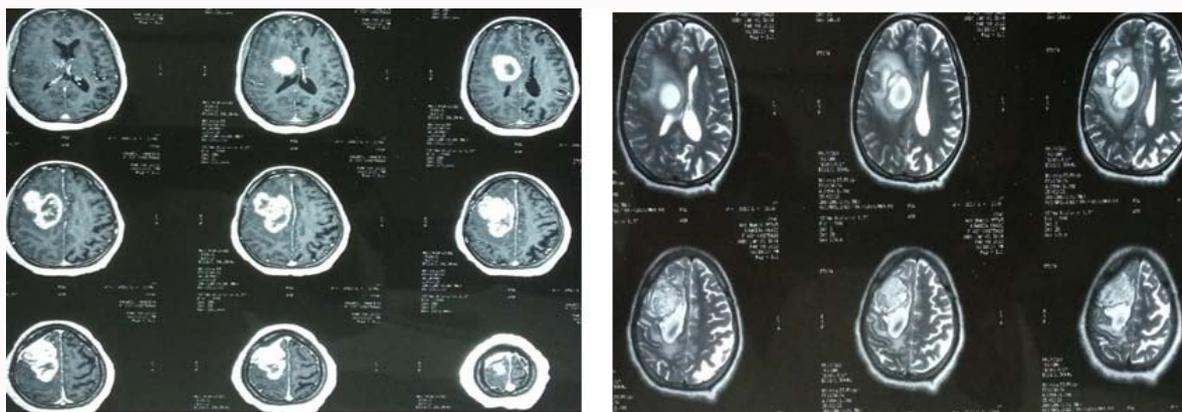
Cerebral MRI. Axial section, T1 (left) and T2 (right)-weighted showing a hyperintense right frontal lesion with a meningeal enhancement and a perilesional edema.
